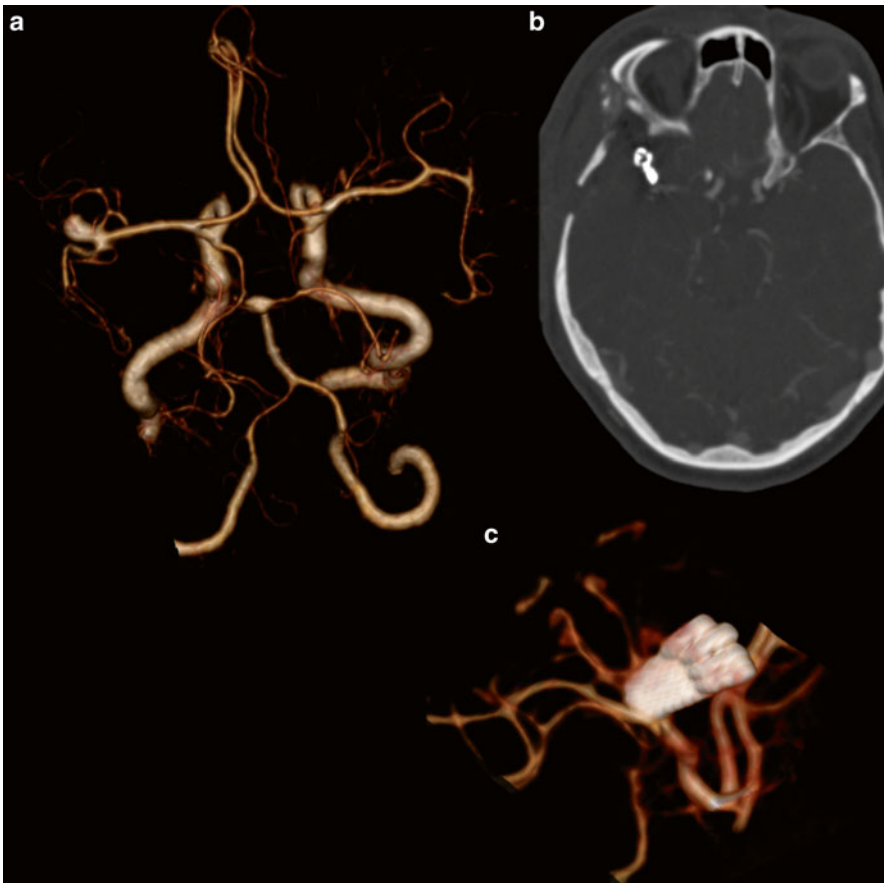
Sixty-seven y/o female underwent a CTA for evaluation of an incidentally found large middle cerebral artery aneurysm (a, bone-removed DE-CTA). She underwent surgical clipping. Source images of the CTA (b) demonstrate the presence of several clips, and 3D visualization of the data reveals four surgical clips at the aneurysm (c), with no signs of residual aneurysm
